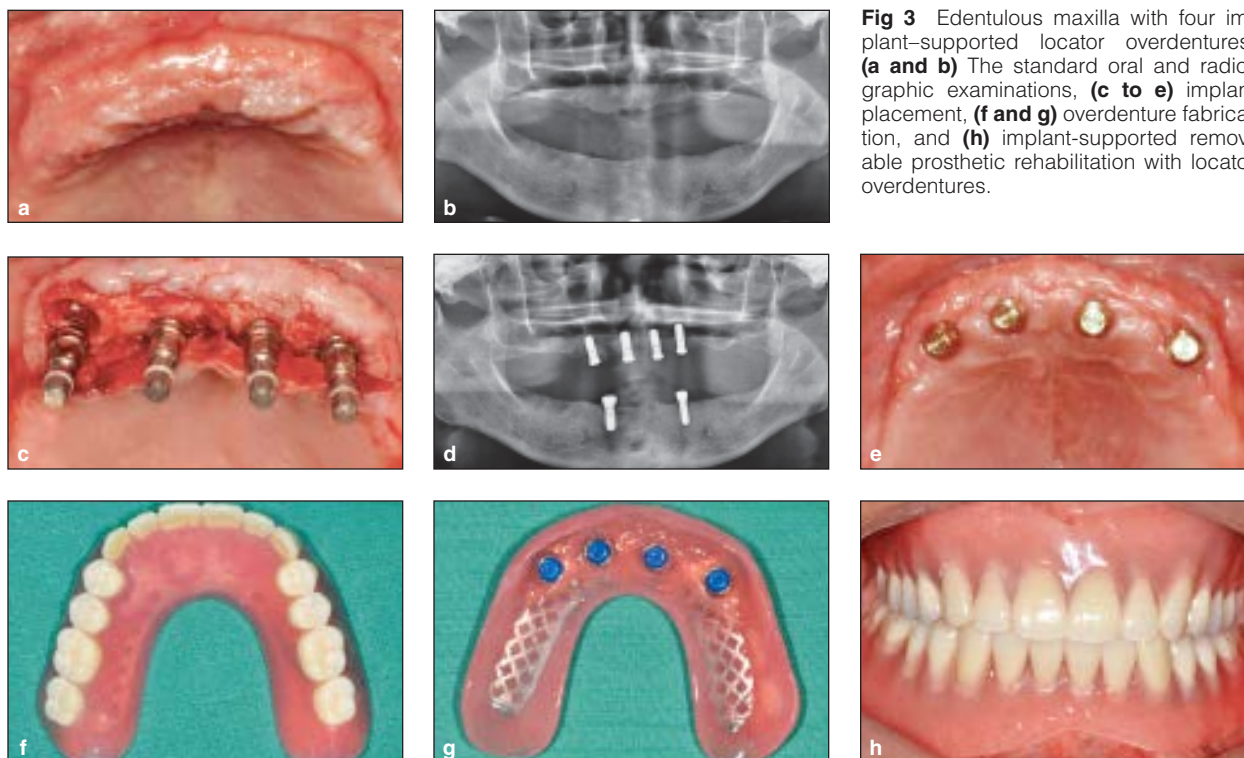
Edentulous maxilla with four implant-supported locator overdentures. (a and b) The standard oral and radiographic examinations, (c to e) implant placement, (f and g) overdenture fabrication, and (h) implant-supported removable prosthetic rehabilitation with locator overdentures.
